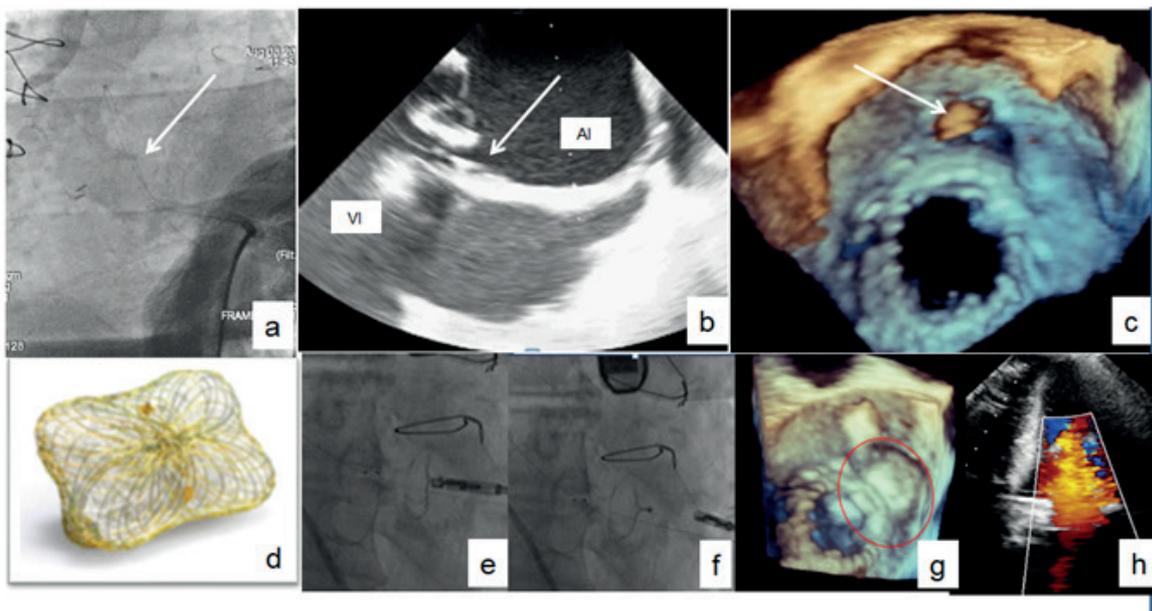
Leak closure via transapical access. a and b) Radioscopy and TEE: HTF2 guidewire crossing the defect (arrow) from the LV towards the LA. c) 3D TEE "en face" confirming the guidewire passage (arrow) through the leak. d) Occlutech PLD (14 W) occluder device. e) Device connected to the delivery system. f) Device delivered. g) 3D TEE "en face": properly positioned device (circle). h) Echo-Doppler study: fewer leak. AI: left atrial. VI: left ventricle.
